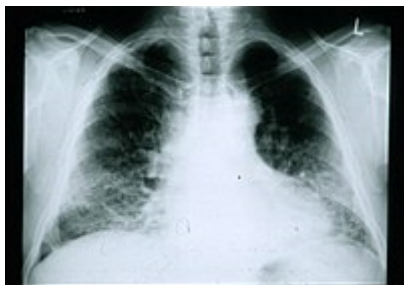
A chest radiograph of a patient with IPF. Note the small lung fields and peripheral pattern of reticulonodular opacification.
